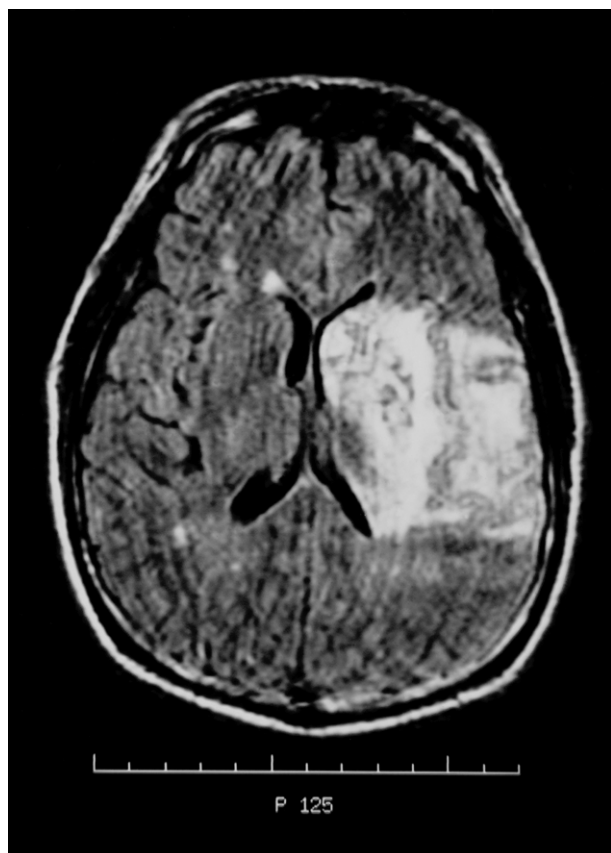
MRI/MRA brain scan demonstrated an extensive infarct, in the distribution of the left middle cerebral artery.
